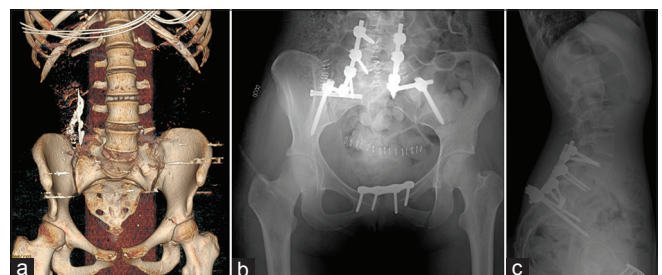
(a-c) X-ray after anterior pelvic ring fixation
